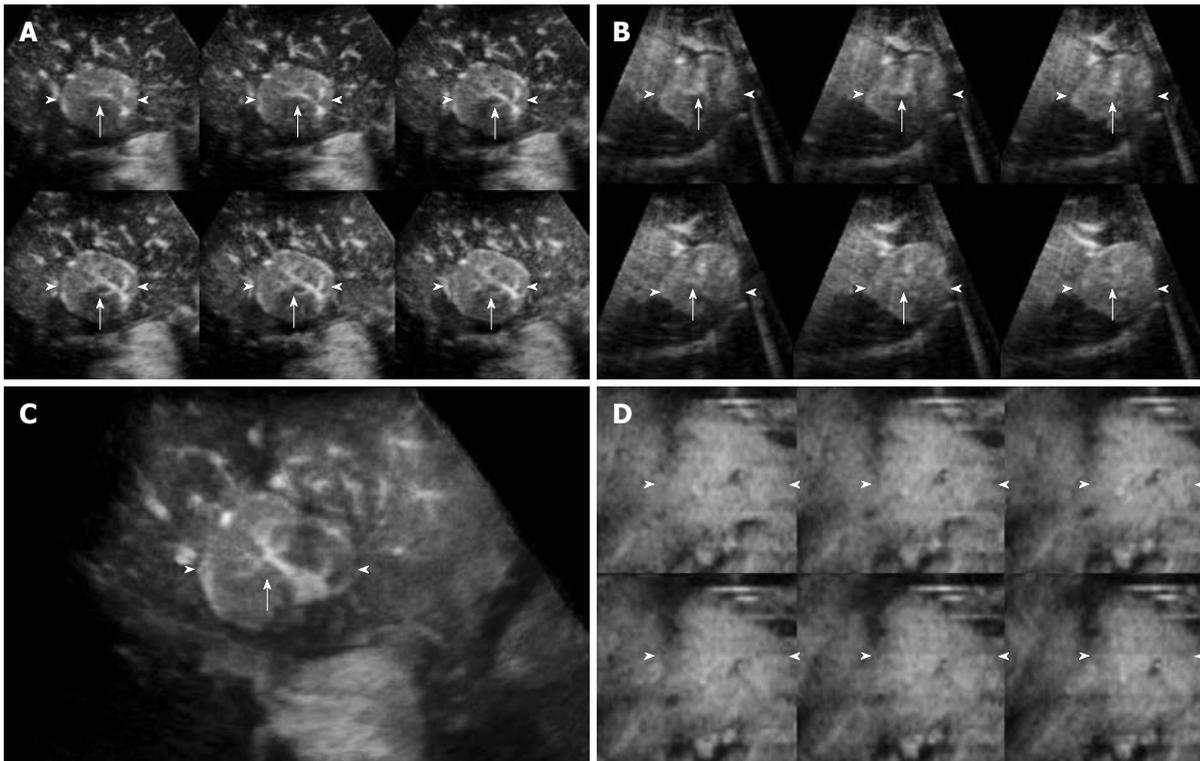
CE 3D US images of the liver in a 77-year-old man with FNH in the medial segment of the left lobe. A-C: TUI in plane A with slice distance 1.5 mm (A) and plane B with slice distance 1.5 mm (B), and the sonographic angiogram rendered by maximum intensity with surface mode (C) show diffuse enhancement with spoke-wheel arteries (arrows) in the early phase; D: TUI in plane C with slice distance 2.5 mm show isoechoic pattern in the late phase and hypoechoic regions within the tumor indicate central scars. Persistent enhancement over time was detected in this lesion. Arrowheads indicate the tumor margin.
